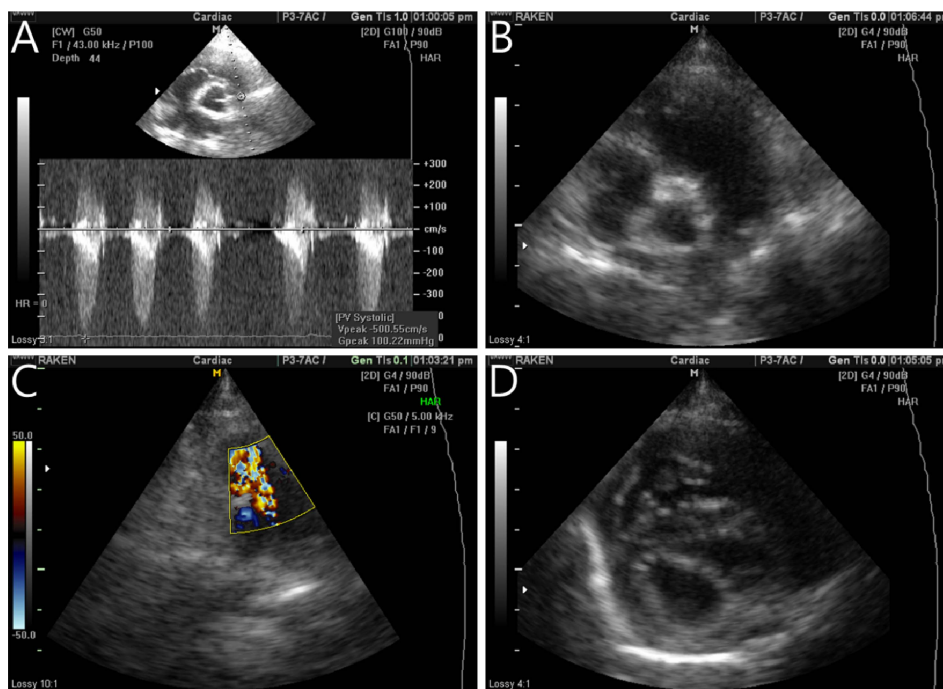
The echocardiography of this case. A: Continuous wave Doppler echocardiography revealed systolic jet flow with velocity of 5.0 m/s (pressure gradient between RV and RVOT 100 mmHg), indicating severe pulmonic stenosis. B: The 2-dimensional echocardiography in right parasternal short axis view revealed narrowing of RVOT (aortic to pulmonary ratio 1.3). C: Color image echocardiography revealed mosaic pattern turbulent jet flow around RVOT. D: The 2-dimensional echocardiography in right parasternal short axis view found RV hypertrophy and interventricular septal flattening, due to pressure overload in the RV. RV, right ventricle; RVOT, right ventricular outflow tract.
